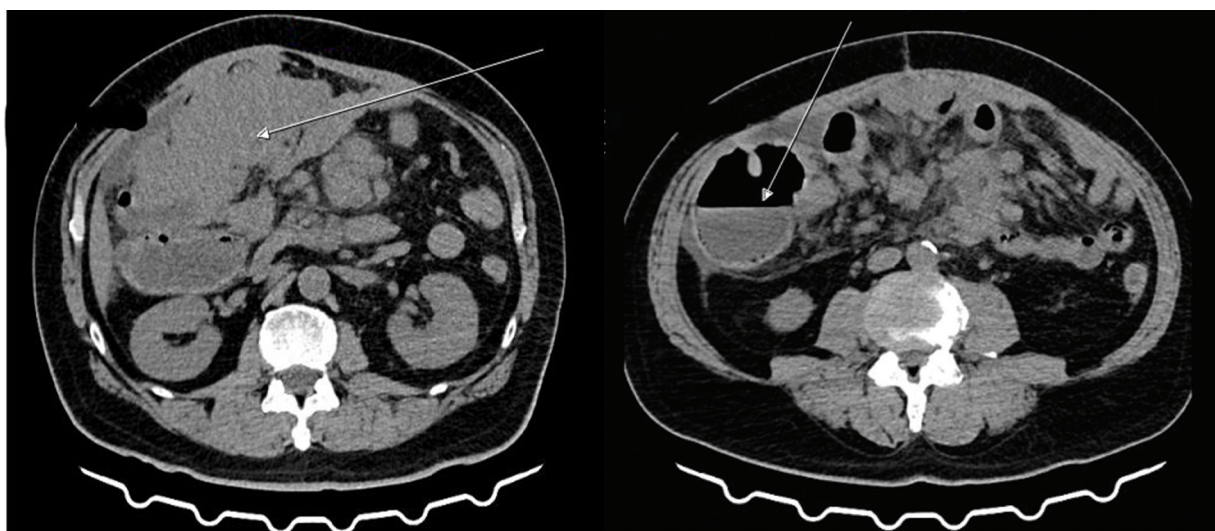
Abdominal CT coronal view. \a\ a conglomerate of intestinal loops with adhesions and pathologically enlarged lymph nodes (arrow) \b\ dilated colon (arrow).
